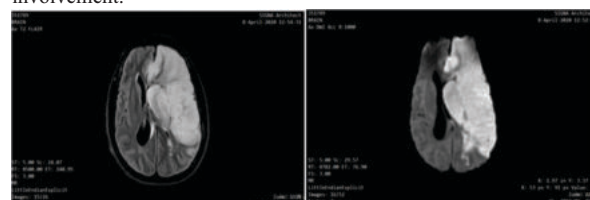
MRI of 40 year female with restriction seen on DWI and hyperintensity on FLAIR in left MCA territory with mid line shift s/o acute infarct.
